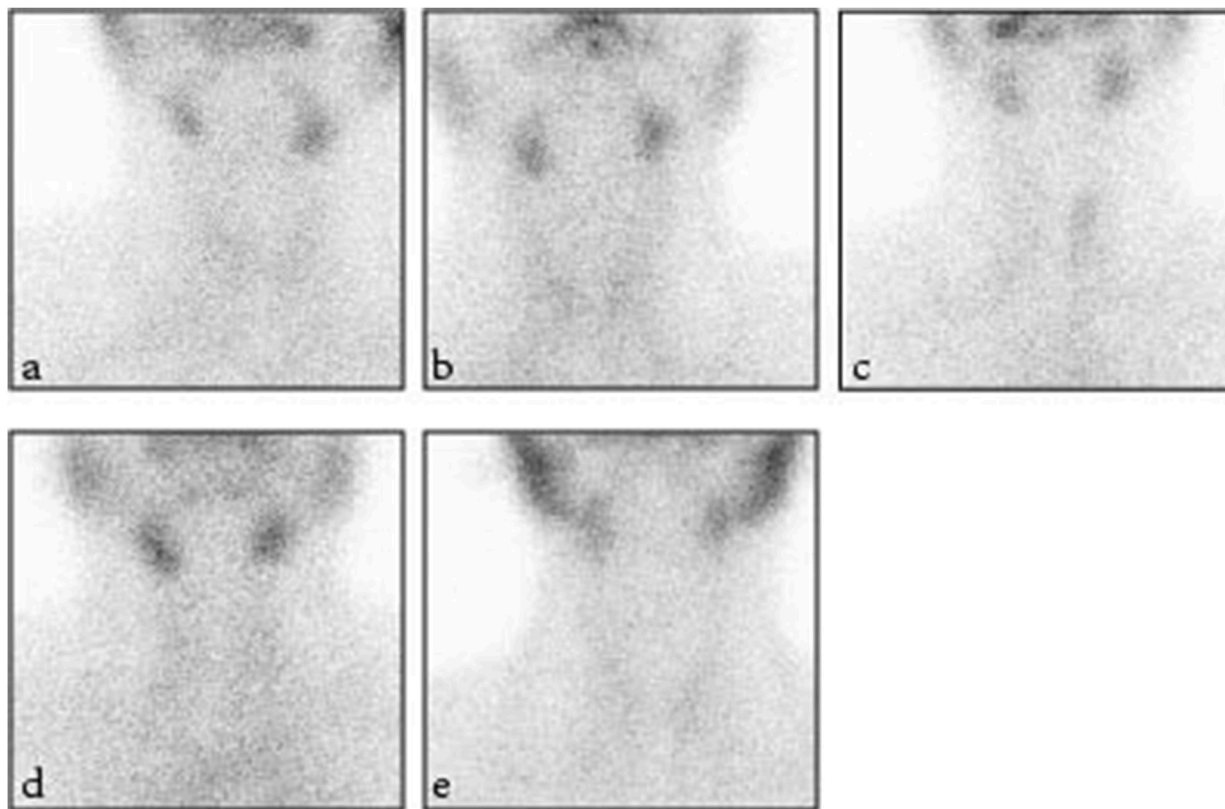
Thyroid scintigraphy images of the cases (a.b.c.d.e). the suppressed thyroid gland was detected in 99mTc pertechnetate thyroid scintigraphy imaging.
